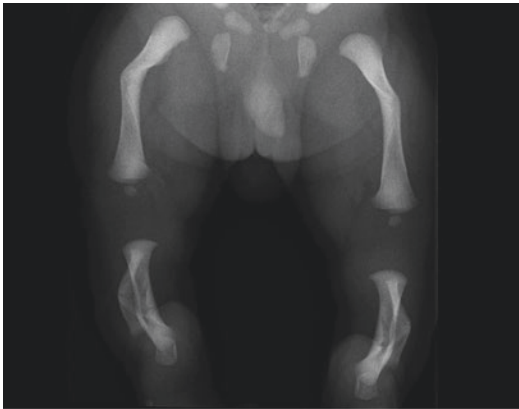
Camp(t)omelic dysplasia. Anteroposterior X-ray of both legs. Anterolateral bowing of both femurs and lower legs with equinus feet in a newborn child
